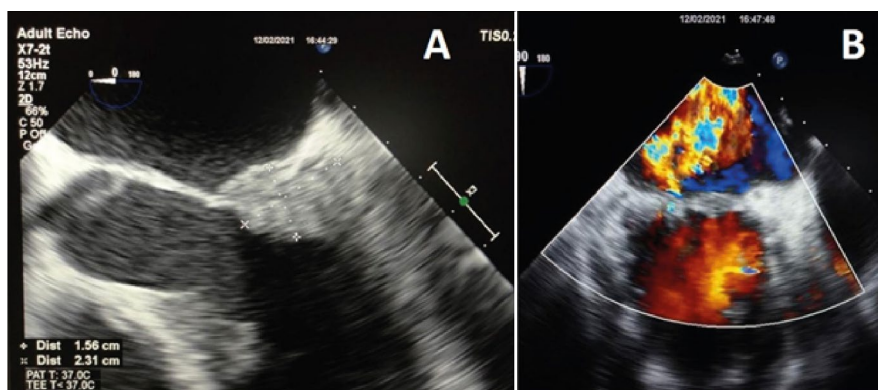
Transesophageal echocardiography A: four-chamber view at 0° showing a sessile image in the posterior mitral valve leaflet measuring 1.56 × 2.31 cm. B: two-chamber view at 90° demonstrating moderate to severe reflux toward the posterior wall of the left atrium.
